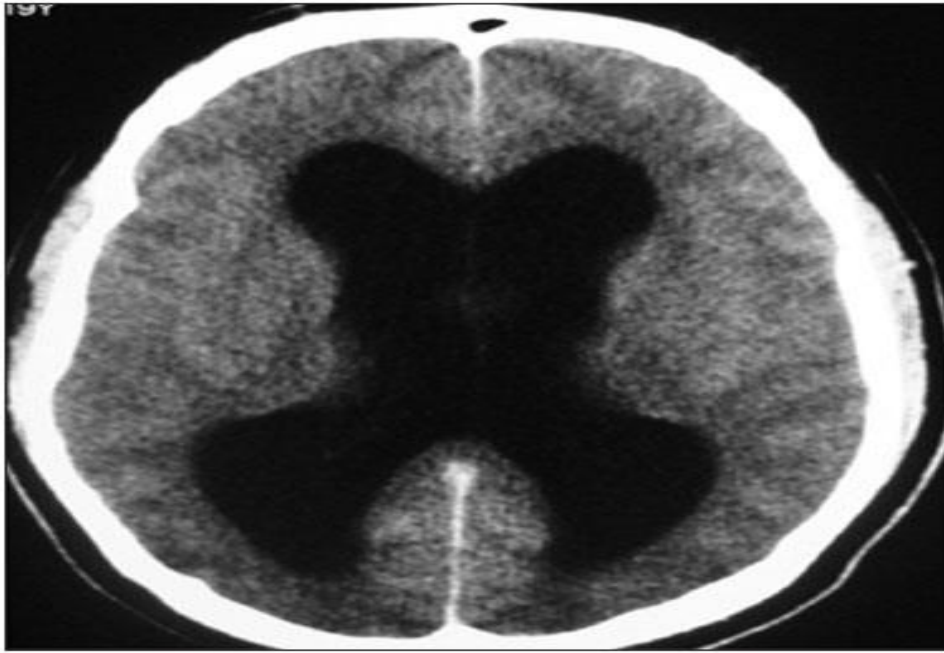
CT scan shows cerebral atrophy.
